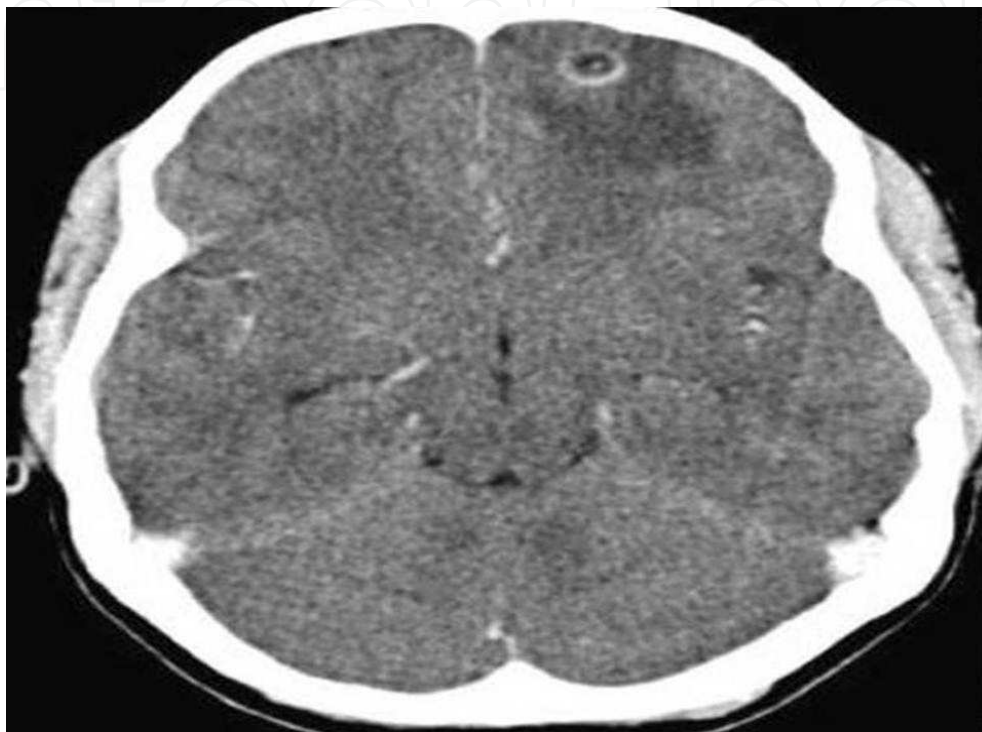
CT scans of the brain show SSECTL on the left frontal lobe with perilesional oedema
